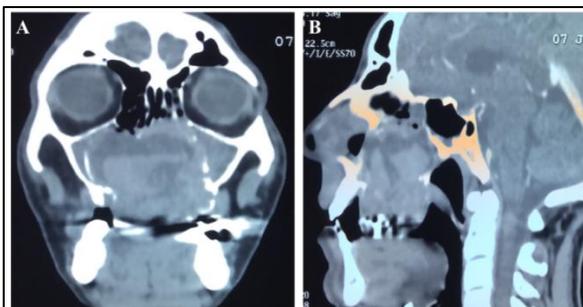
Huge mixed lesion in maxillary and ethmoid sinuses, nasal cavities and entire hard palate in coronal (A) and sagittal (B) slices of computed tomography view
